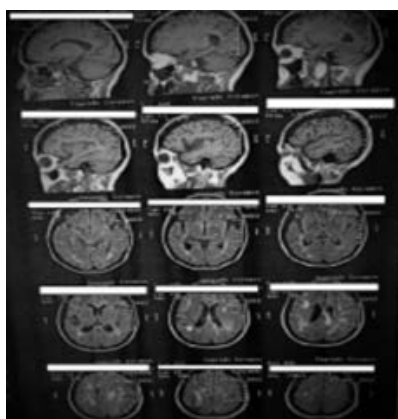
Brain MRI scan showing a gradual radiological recovery after the first month of corticosteroid treatment.
